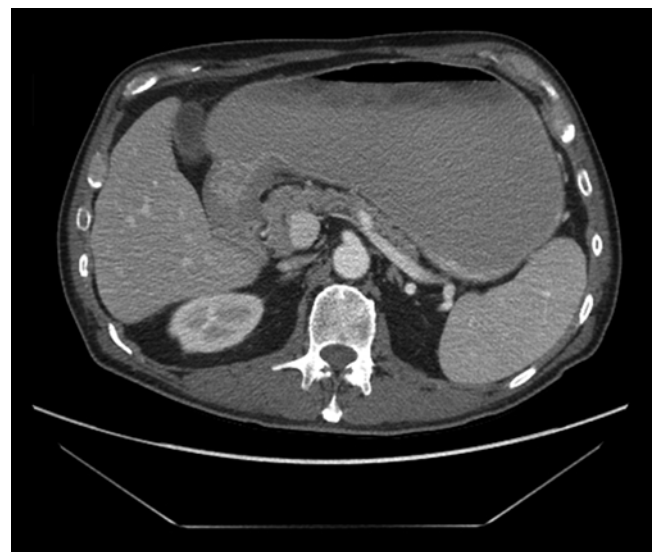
CT image demonstrating gastric outlet obstruction
